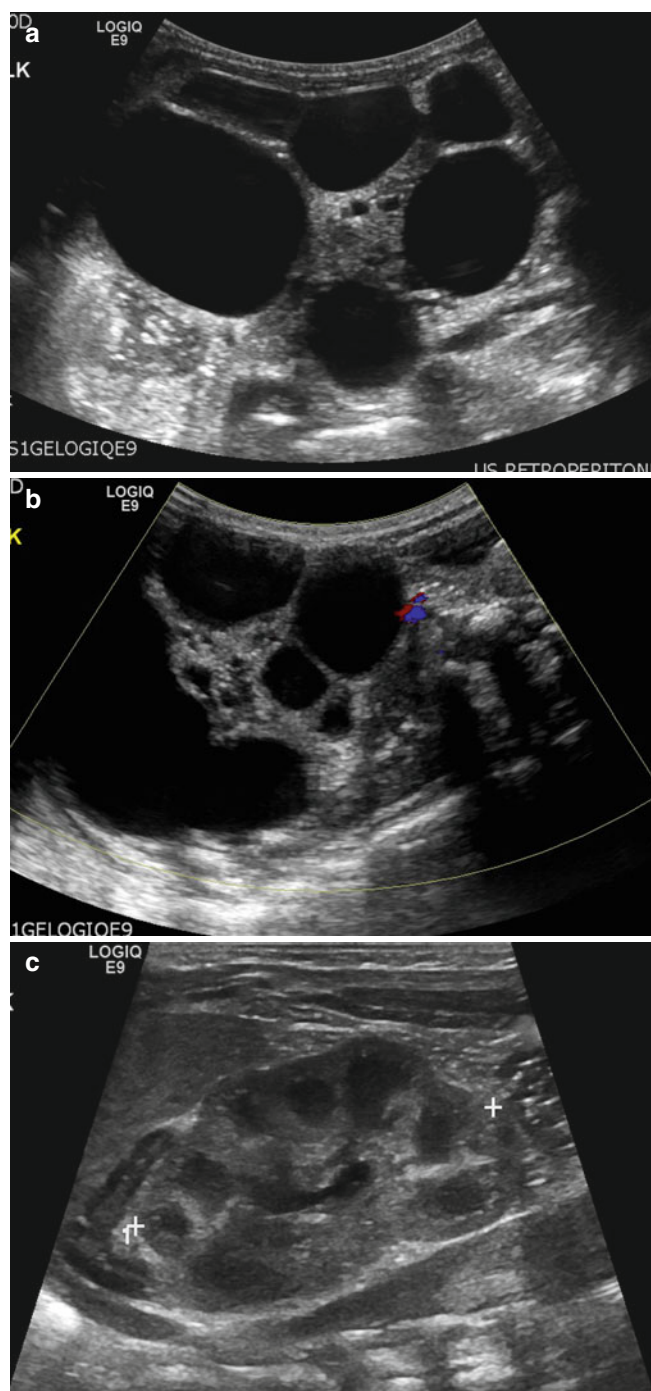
Multicystic dysplastic kidney in a 1-day-old girl. (a) Longitudinal US of the left kidney shows multiple cysts of varying size and intervening hyperechoic area. Left kidney measures about 9.4 cm in length. Normal renal parenchyma is not demonstrated. (b) Color Doppler US of the left kidney shows no vascular structure within the intervening hyperechoic area. (c) Longitudinal US of the right kidney shows normal renal parenchyma. Right kidney measures about 4.0 cm in length
